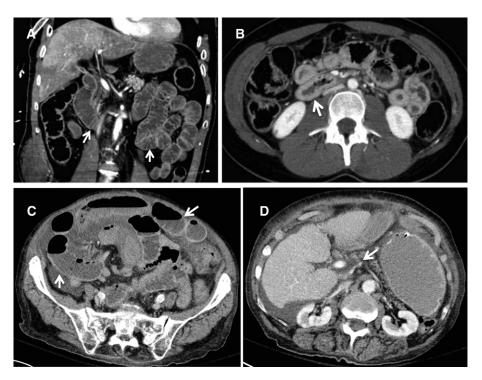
(A) Coronal contrast-enhanced abdominal computed tomography of a patient who presented with hypovolemic shock, showing dilated fluid-filled bowel loops consistent with shock bowel (arrows). (B) Axial slice from the same patient, demonstrating bowel wall thickening and increased enhancement (arrow). These findings are in line with hypovolemic shock complex. Compare with (C) and (D) from a 73-year-old patient with bowel ischemia. (C) Dilated, fluid-filled small bowel loops are present (arrows), which mimic the findings of shock bowel in hypovolemic shock. However, the presence of an occluded superior mesenteric artery (D, arrow) suggests a diagnosis of bowel ischemia rather than shock bowel.
